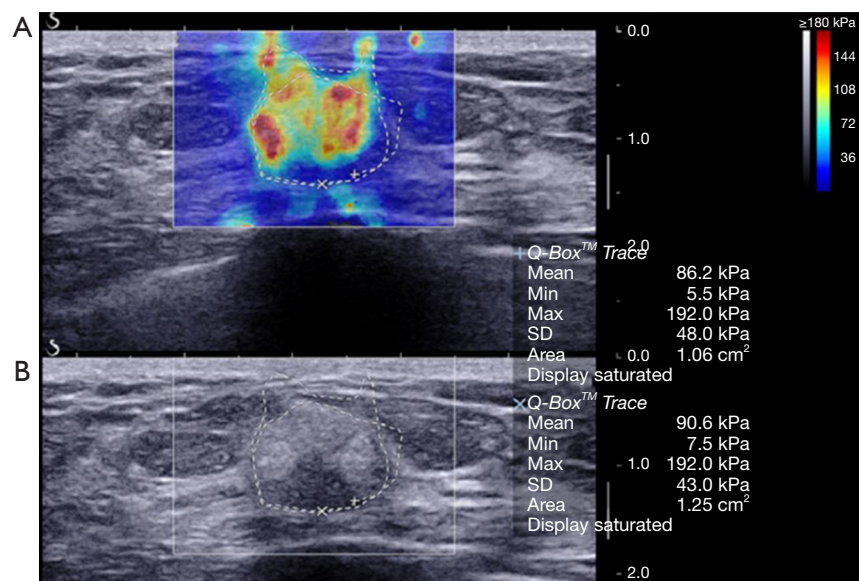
A 64-year-old woman with a grade II invasive ductal carcinoma. US image (B) shows a 14 mm hypoechoic mass with an indistinct margin classified as BI-RADS category 4a. SWE image (A) shows Emax of 192.0 kPa. The mass would be upgraded to BI-RADS category 4b by using the aggressive and conservative approaches. SD, standard deviation; US, ultrasound; BI-RADS, Breast Imaging-Reporting and Data System; SWE, shear-wave elastography; Emax, maximum elasticity.
